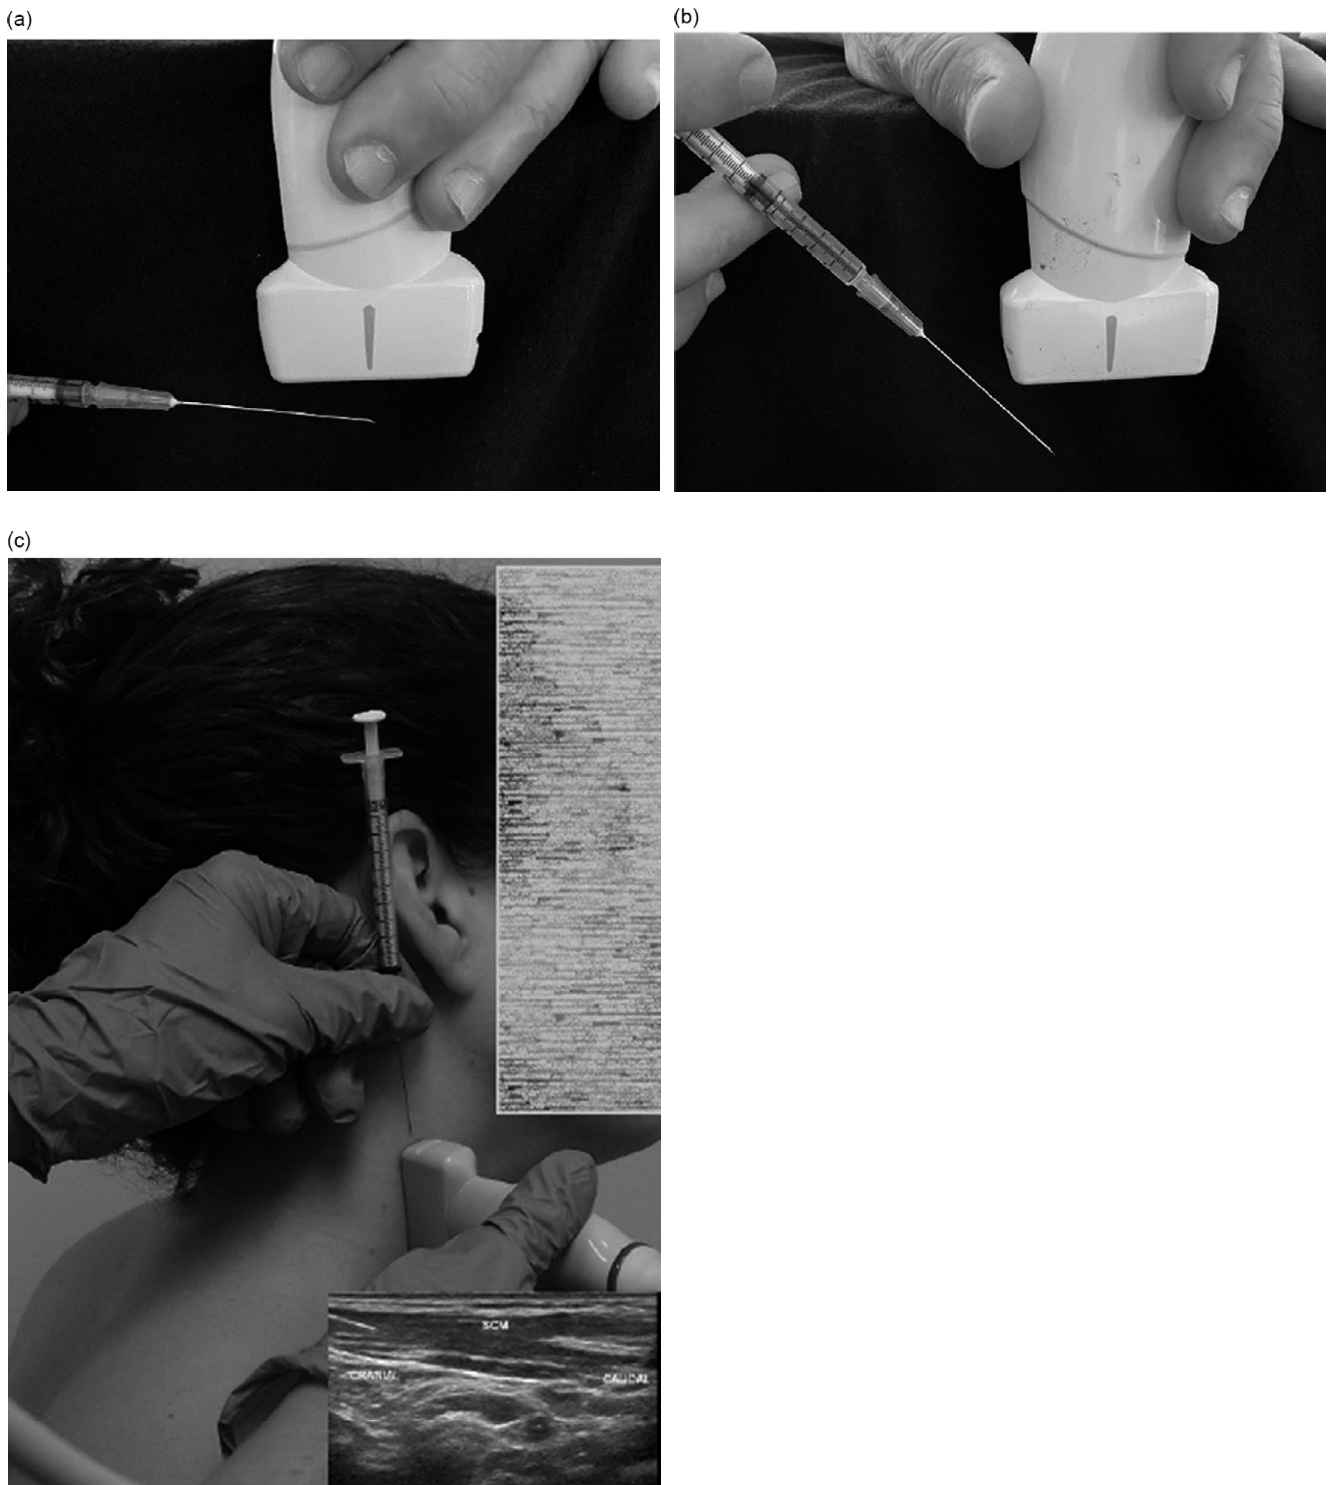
(a) In-plane technique with flat angle of needle insertion. (b) In-plane technique with shallow angle of needle insertion. (c) In-plane view of needle, sternocleidomastoid muscle, long-axis ultrasound scan.
